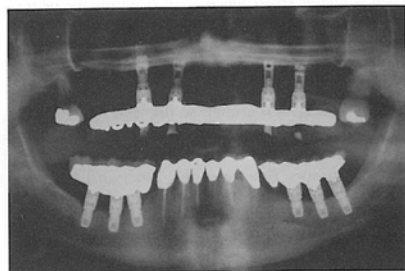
Panoramic radiograph shows bone levels at or near the first thread of Brånemark System implants 1 year following prosthesis placement.
